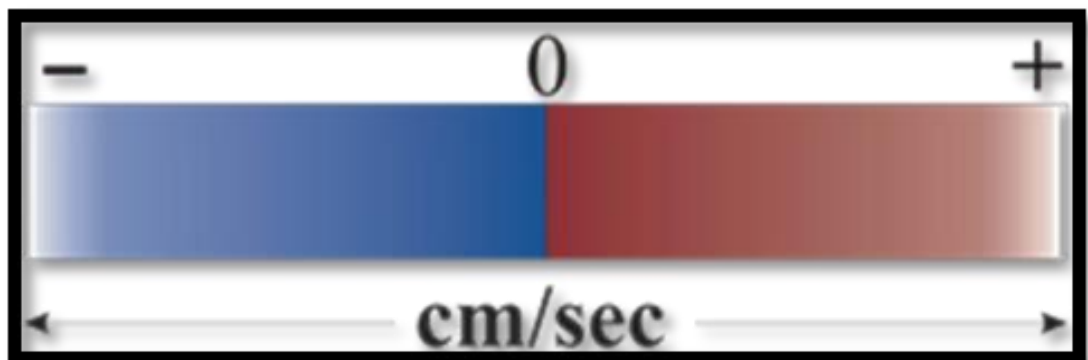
Two colour doppler ultrasound.
